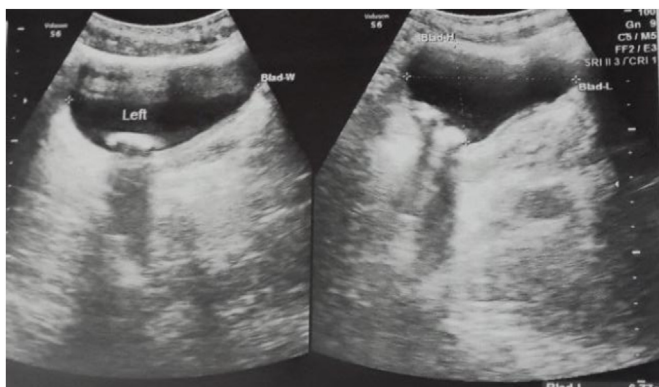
Ultrasound abdomen showing multiple foreign body in urinary bladder.
